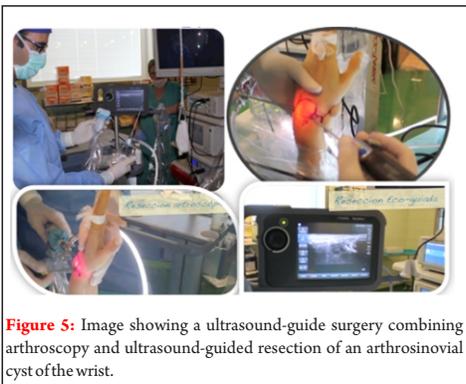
Image showing a ultrasound-guide surgery combining arthroscopy and ultrasound-guided resection of an arthrosinovial cyst of the wrist.
